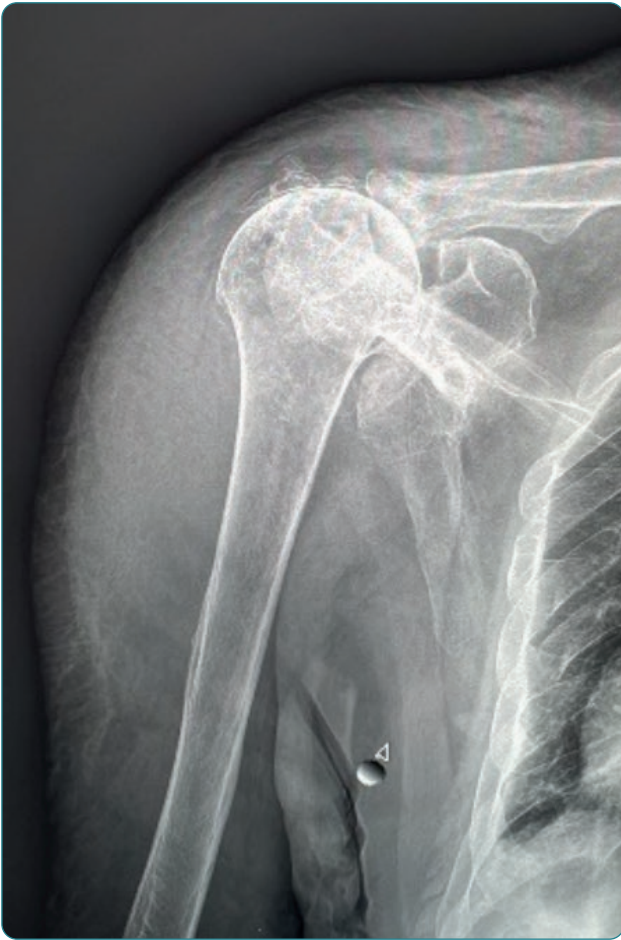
Patient with shoulder osteoarthritis. X-ray in lateral projection.
